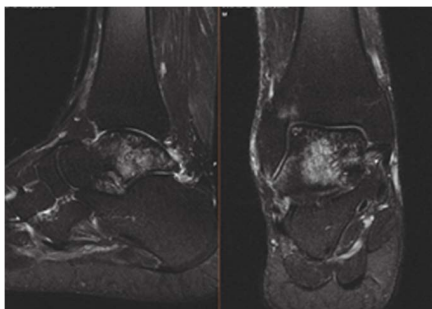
Right Ankle MRI April 2021
